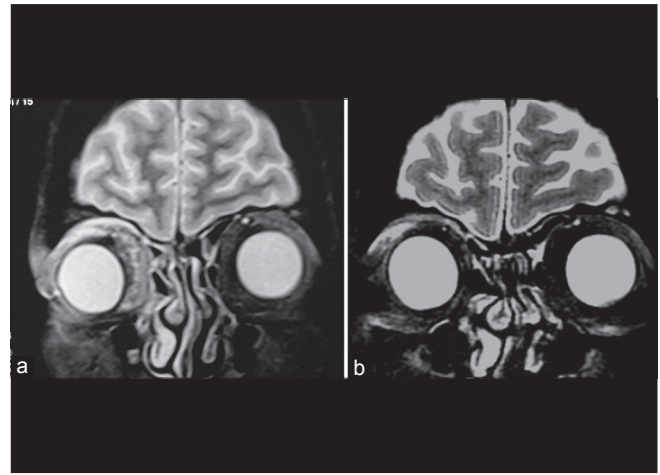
(a) Magnetic resonance imaging: Soft tissue lesion in the supero-medial extraconal orbit (Pre-treatment), (b) Post-treatment showing resolution of the lesion
